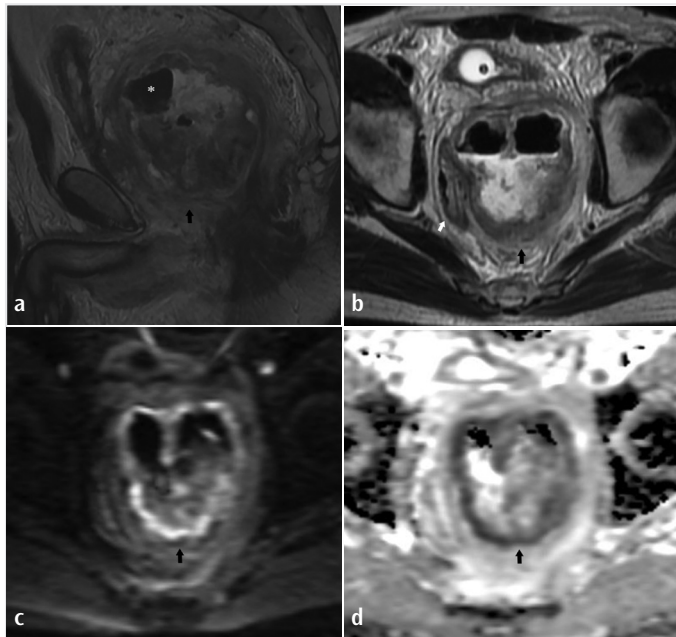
Air (*) inside the ulcerated rectal GIST (black arrow) which shows peripheral hypo-intensity and heterogeneous central hyper-intensity on sagittal T2-weighted sequence.
